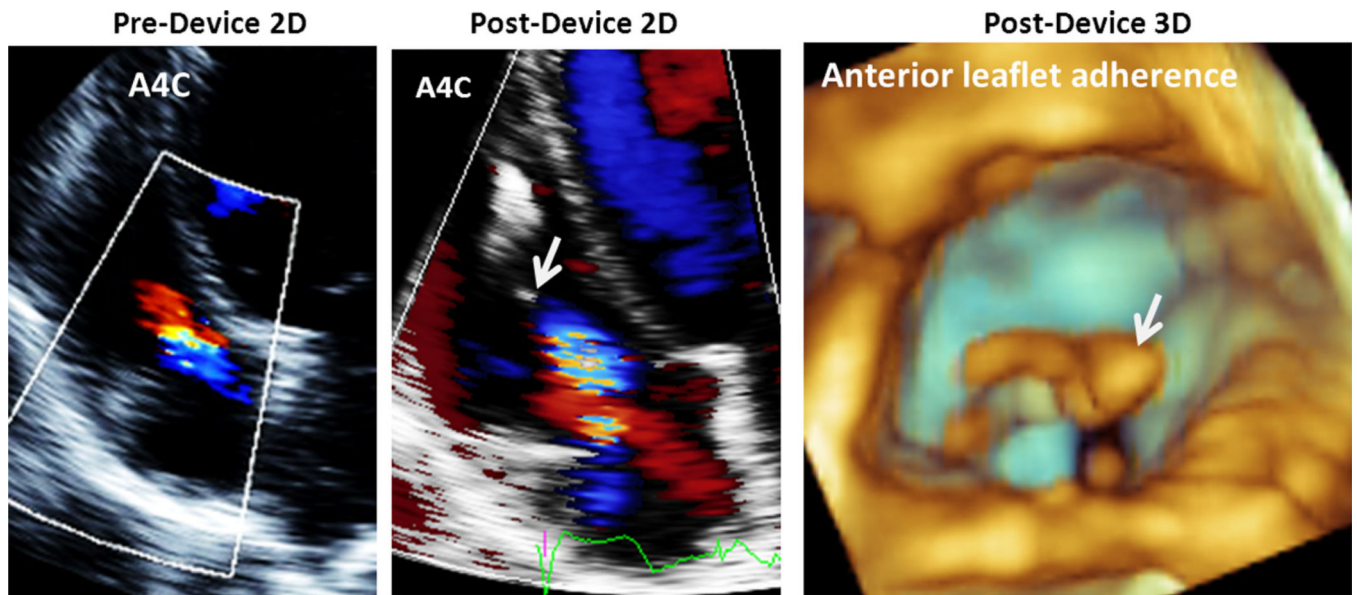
Anterior leaflet adherence. Color flow recordings of the TV showing trace TR before device lead placement (*left*) and mild to moderate TR after device lead implantation (*middle*). Three-dimensional zoom (*right*) confirms anterior leaflet adherence of the device lead. *White arrow* points to device lead. *A4C*, Apical four-chamber. See also Video 2.
